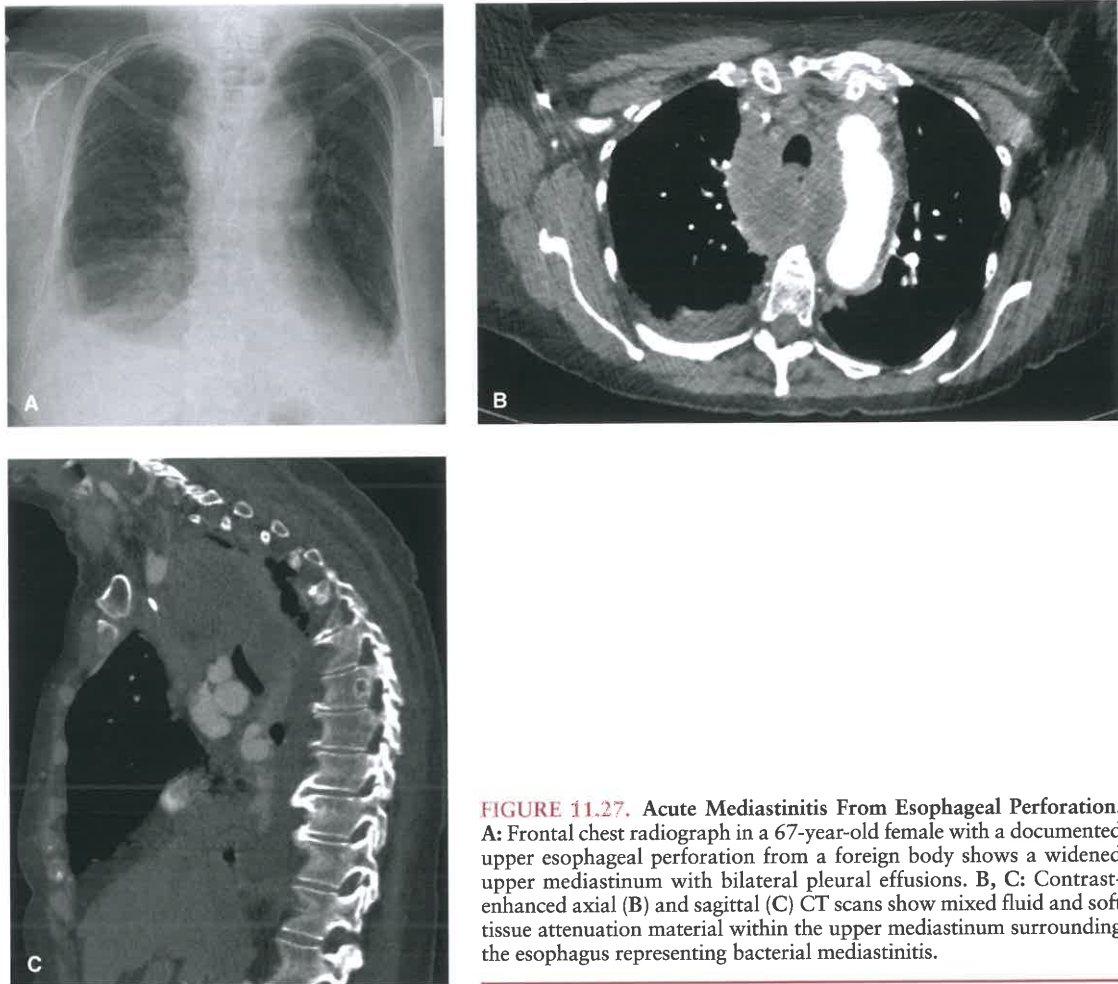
Acute Mediastinitis From Esophageal Perforation. A: Frontal chest radiograph in a 67-year-old female with a documented upper esophageal perforation from a foreign body shows a widened upper mediastinum with bilateral pleural effusions. B, C: Contrast-enhanced axial (B) and sagittal (C) CT scans show mixed fluid and soft tissue attenuation material within the upper mediastinum surrounding the esophagus representing bacterial mediastinitis.
